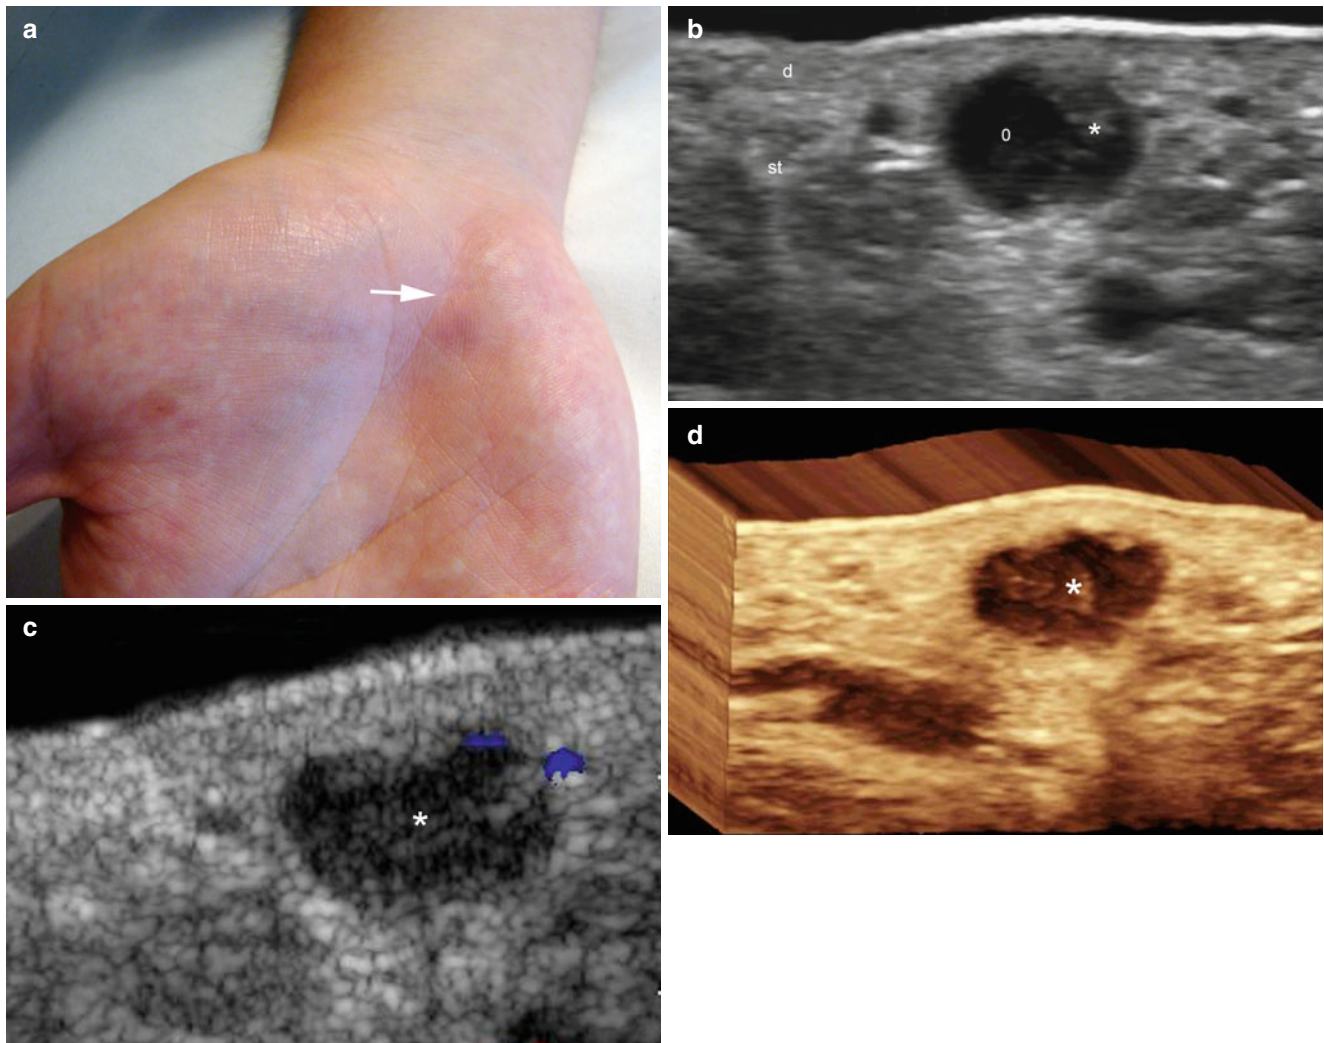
(a–d) Schwannoma. (a) Clinical image shows a skin-colored swelling in the palmar aspect of the right hand (*arrow*). (b) Grey scale ultrasound image (transverse view) demonstrates a well-defined nodule in the subcutaneous tissue that presents mixed echogenicity
